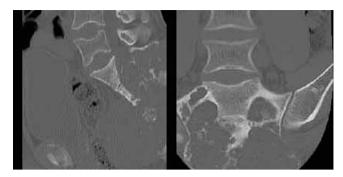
CT scan delineates extent of lesion and shows sacroiliac joint involvement. MRI (T2) findings show a large hyper-intense inhomogeneous mass with a pseudocapsule (Fig.5). The mass is usually lobulated or may be multilobulated 12 , 14 , $^{19-22}$. MRI should include the entire pelvis as well as the abdomen. Santos-Rancano et.al highlighted.
